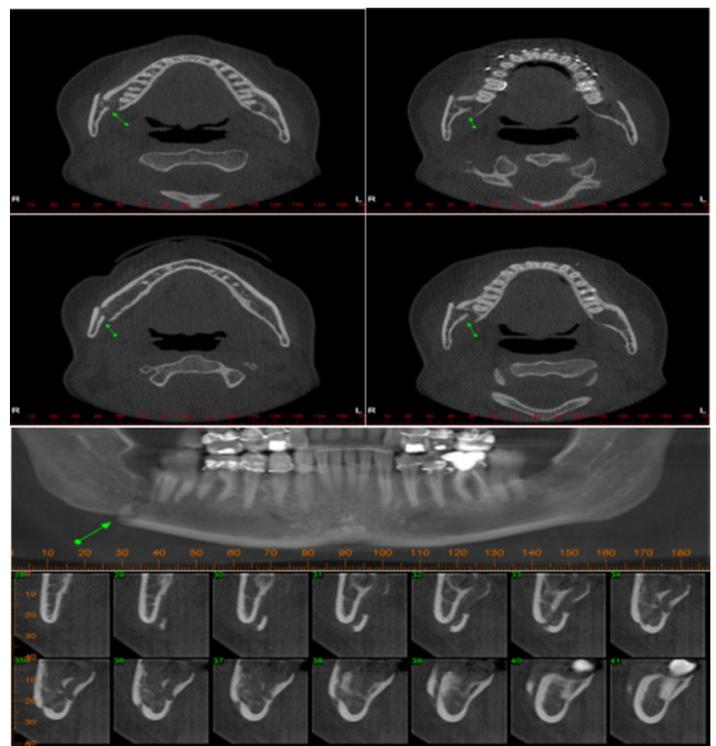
Cone-beam CT scan obtained 45 days after maxillomandibular fixation.
